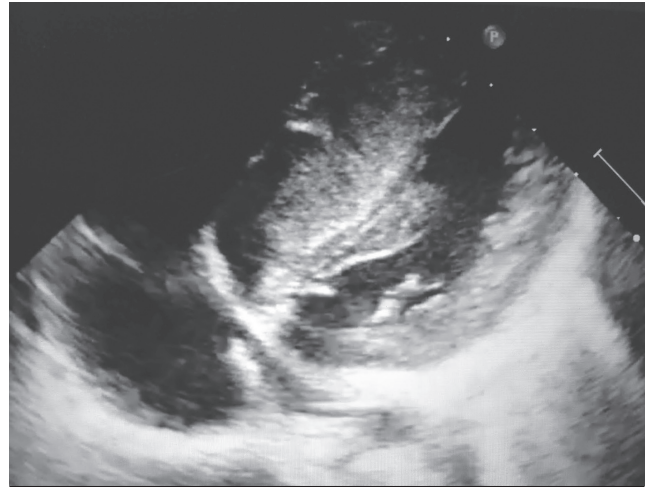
Echocardiographic examination shows that the left ventricle cavity is smaller than normal and there is a significant hypertrophy in the septum
